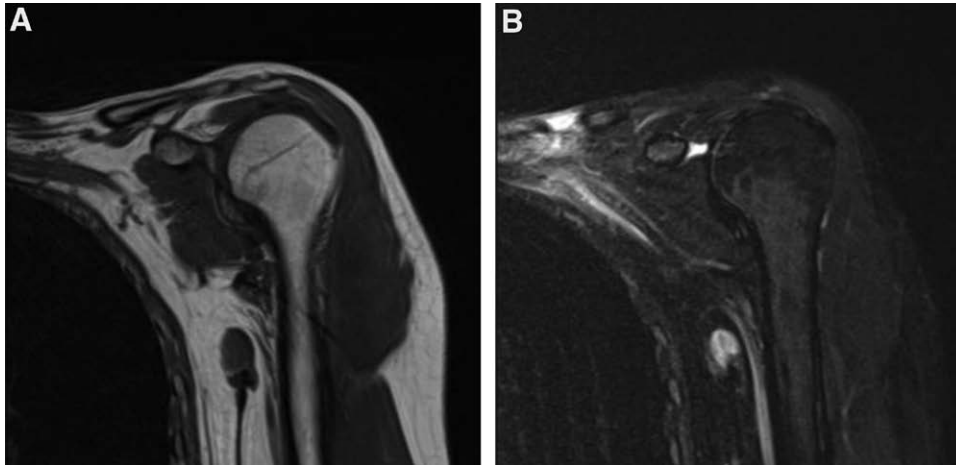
MRI at the initial visit showing a well-defined oval soft-tissue mass in the subcutaneous tissue of the left axilla of a 36-year-old woman. A, T1. B, T2.
